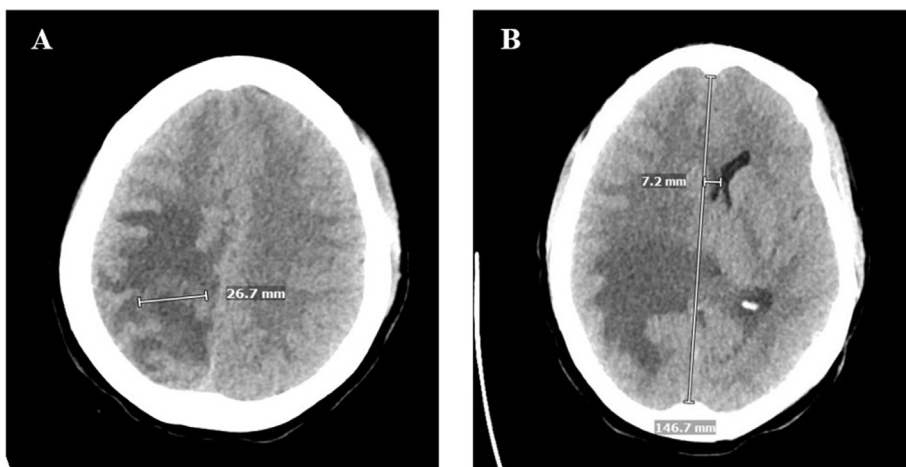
A: Computerized tomographic (CT) imaging of head without contrast showing right parietal lobe ill-defined mass with substantial surrounding vasogenic edema. B: Computerized tomographic (CT) imaging of head without contrast showing 7 mm leftward midline shift at the level of the septum pellucidum.
